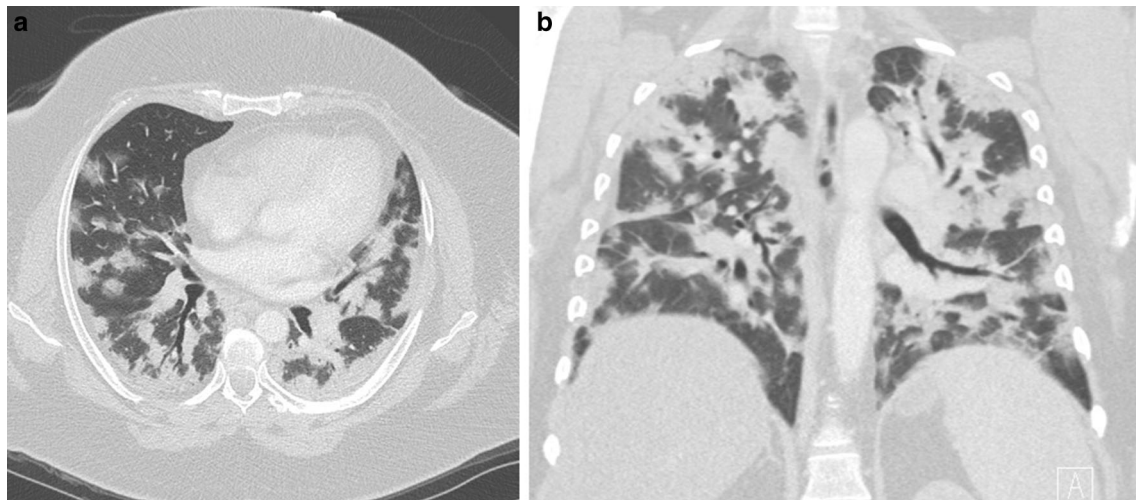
A 42-year-old female who initially presented with fever and shortness of breath. a Axial and b coronal CT of the chest demonstrate diffuse peribronchovascular consolidation on CT, subsequently confirmed as H1N1 viral pneumonia
